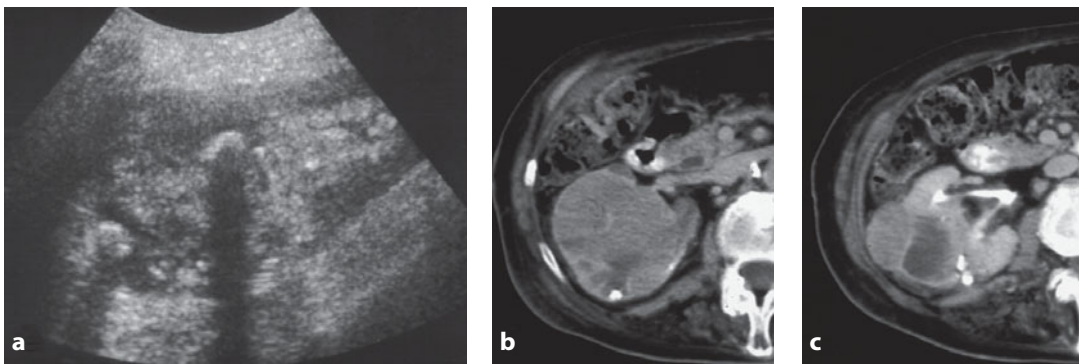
Ultrasonography and contrast-enhanced CT. Xanthogranulomatous pyelonephritis. a US study shows renal enlargement limited to the superior sectors associated with several hypoechoic areas and the presence of two stone formations. b-c CT images show diffuse and nonuniform hypoattenuation of the superior half of the kidney, with the presence of above-fluid attenuating collections and stone formations. Renal function is conserved, as seen by the presence of contrast medium in the renal pelvis, which demonstrates increased wall thickness
